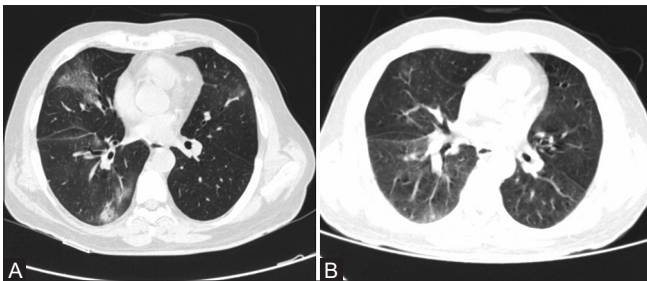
(A and B): (A) Initial HRCT chest of a symptomatic RT-PCR proven COVID patient showing GGOs, focal consolidation, and mild fibrosis in bilateral lungs. (B) HRCT chest of the same patient done 10 days later shows marked resolution of GGO and fibrosis. Patient had improved clinically
